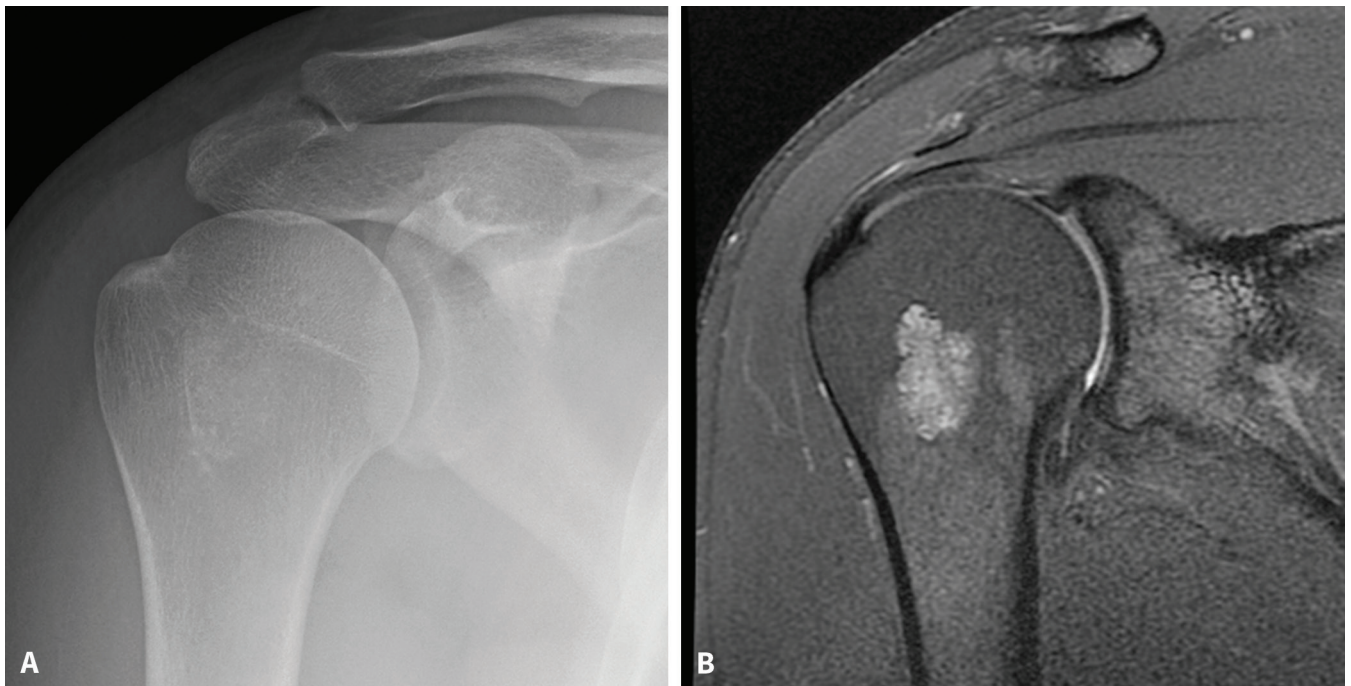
Radiographic (A) and MRI (B) images of an incidental enchondroma of right shoulder.
